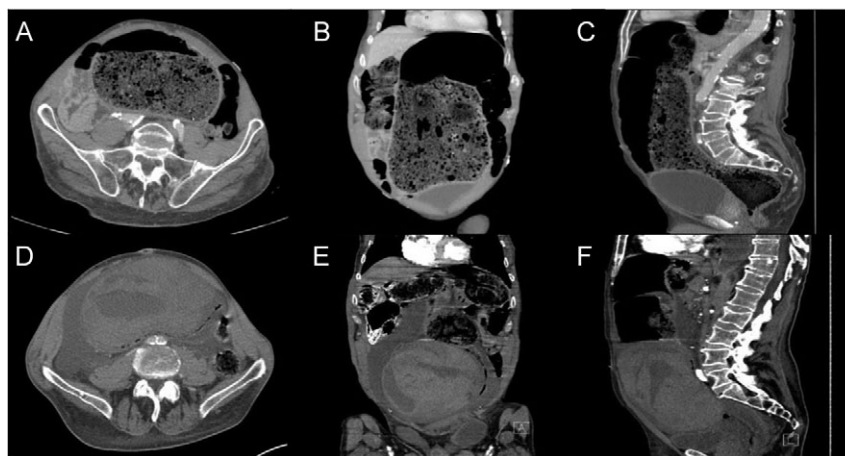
CT – Abdomen and Pelvis with intravenous contrast. Admission imaging demonstrating large colonic stool burden in the axial (A), coronal (B) and sagittal orientation (C). CT abdomen and pelvis following enema demonstrating large colonic wall hematoma axial (D), coronal (E) and sagittal orientation (F).
